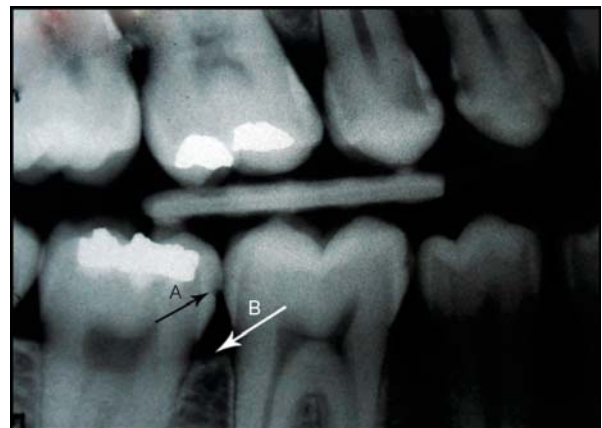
Indications of bite wing radiograph: A: Interproximal caries detection; B: Evaluate the interdental bone
